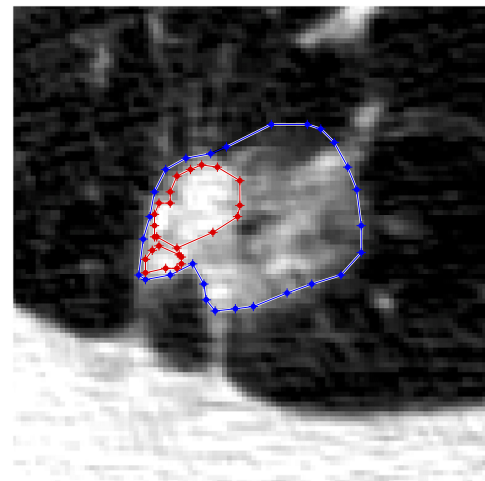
Example of a lesion with GGO (external boundary) and solid (internal) components annotated. The CT slice where the total lesion area was the largest was selected. The GGO region was excluding the two solid ROIs in this case.
